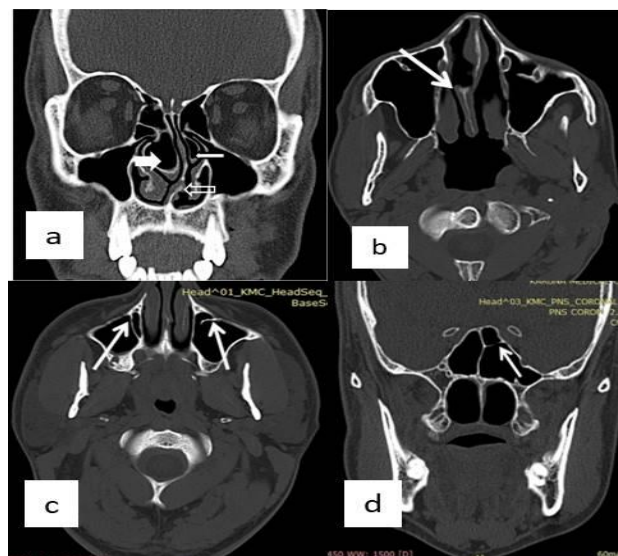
Anatomical variations of the nasal cavity using CT scan images
